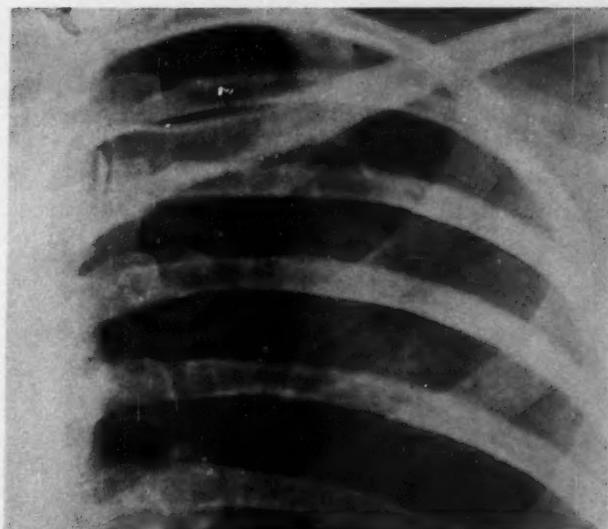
Simple aspergilloma. This radiograph shows a solid shadow with the characteristic crescentic air space above it. There is no obvious abnormality in the surrounding lung.
